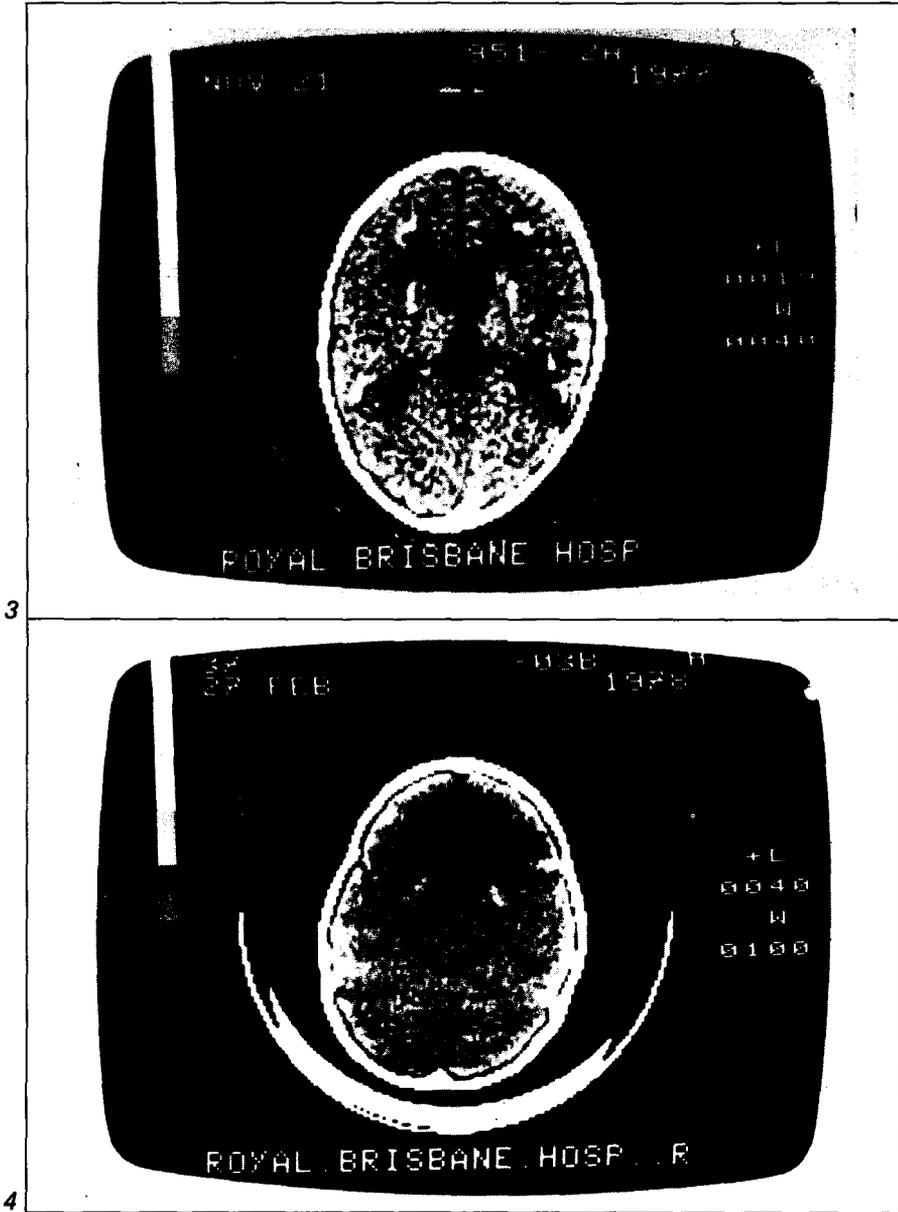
Patient DC. CT scan showing basal ganglion and periventricular calcification which was not evident on plain skull films.
